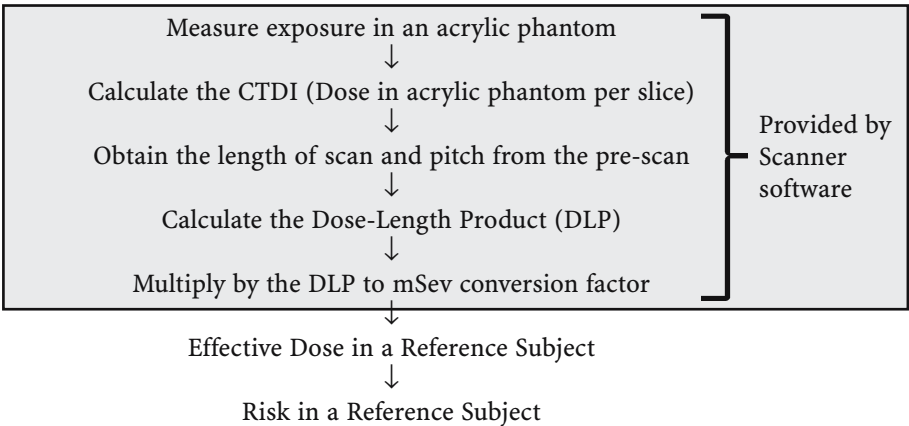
Algorithm for the simple estimation of risk from CT examinations
